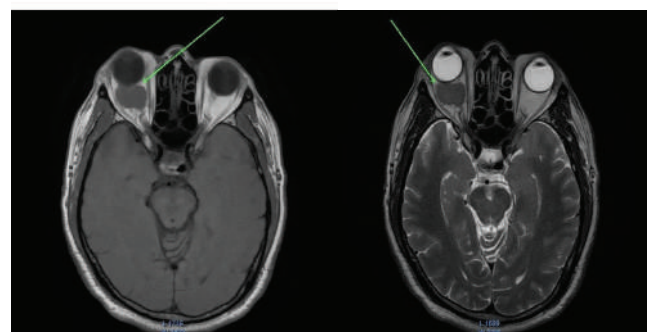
Axial MRI scans of the orbits show a well-circumscribed, ovoid intraconal lesion in the right orbit that is hypointense on T1-weighted image(left) and hyperintense on T2-weighted image(right).
